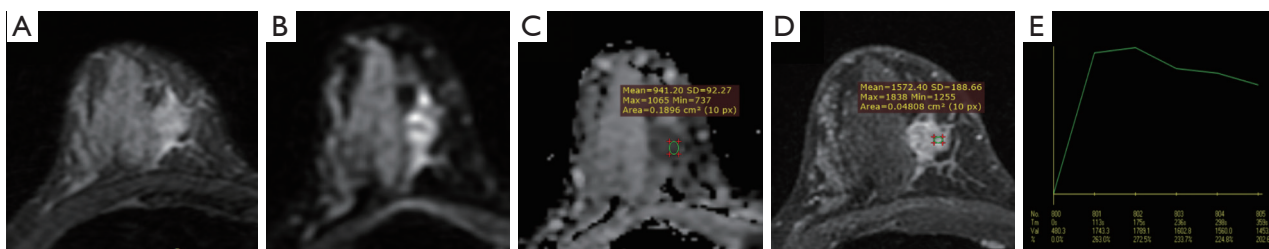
Breast MRI in TNBC female patient, aged 30 years old. (A) T2-dynamic sequence shows an irregular mass in the upper quadrant of the right breast, with an unsmooth edge and visible lobulation and spicules. (B) The DWI image shows a high signal intensity in the mass. (C) The ADC image using a 0.2 cm² circular ROI shows uneven low signal intensity of the tumor, with an average ADC value of approximately 0.941×10⁻³ mm²/s. (D) Enhanced scan shows clustered circular enhancement. (E) TIC shows an outflow type (type III). MRI, magnetic resonance imaging; TNBC, triple-negative breast cancer; DWI, diffusion-weighted imaging; ADC, apparent diffusion coefficient; ROI, region of interest; TIC, time-signal intensity curve.
